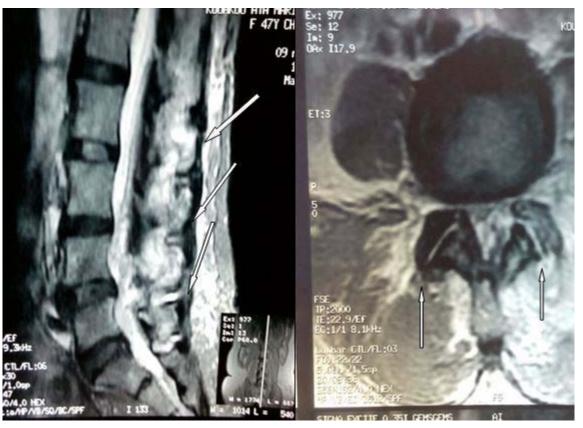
MRI of the lumbar spine showing in T2 sequence with fat suppression, a hyperintensity signal, next to zygapophyseal joints from L2 to S1 associated with taking contrast of zygapophyseal joint L3-L4, most seen in the left joint
